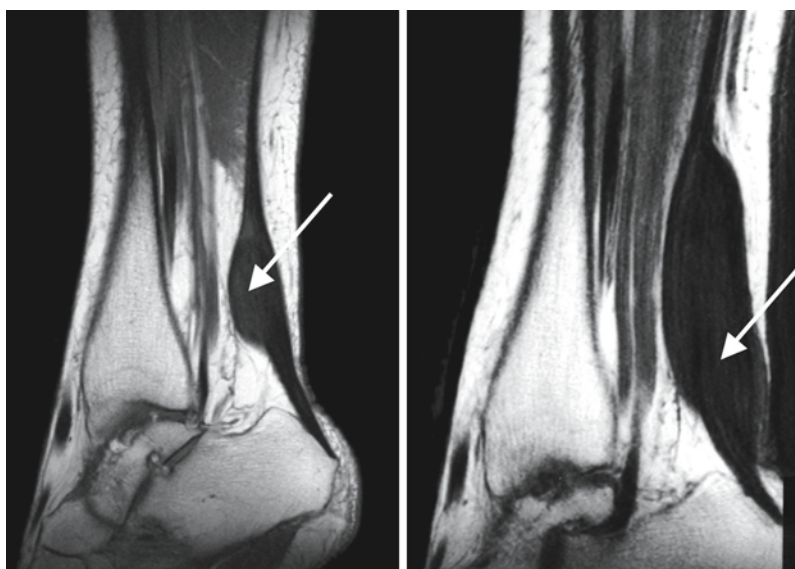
The T1-weighted images show the typical swelling of the Achilles tendon in two CTX patients (arrows). Courtesy of Dr. F. Barkhof, Department of Radiology, VU University Medical Center, Amsterdam, and Dr. A. Verrips, Department of Pediatric Neurology, University Medical Center Nijmegen, The Netherlands
